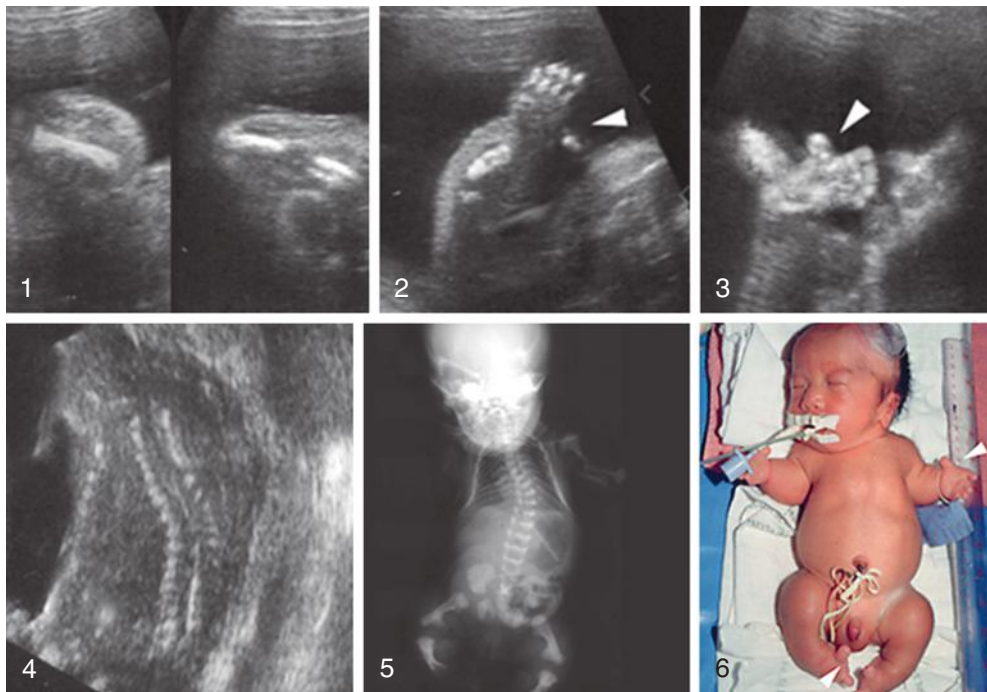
Sonograms of a fetus with diastrophic dysplasia showing short long bones (1), hitchhiker thumb (2), separation of the great toe (3), and kyphoscoliosis (4). Kyphoscoliosis was corroborated after birth (5). Appearance of newborn (6). (Courtesy of Theera Tongsong, MD, and Suchaya Luewan, MD.)
